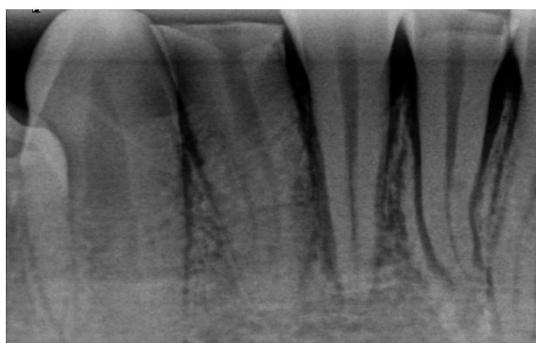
Pre-radiograph of 31,41,42
